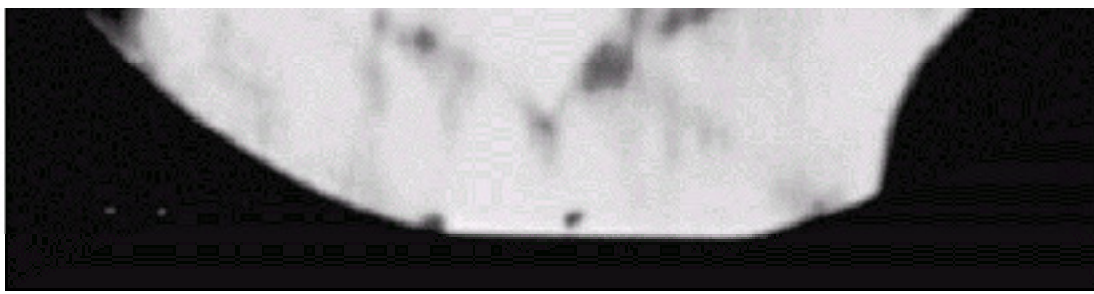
Axial computed tomography scan demonstrating a subperiosteal abscess.
